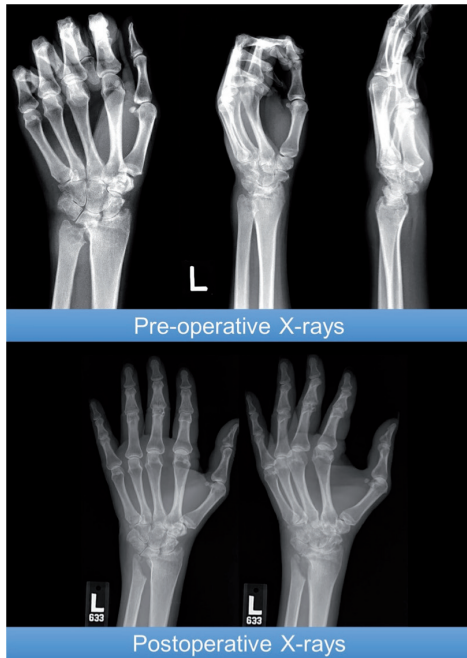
Preoperative and postoperative radiographs of a patient undergoing hemiresection interposition arthroplasty for inflammatory arthritis of the DRUJ. This patient had no complications and did not undergo reoperation.
